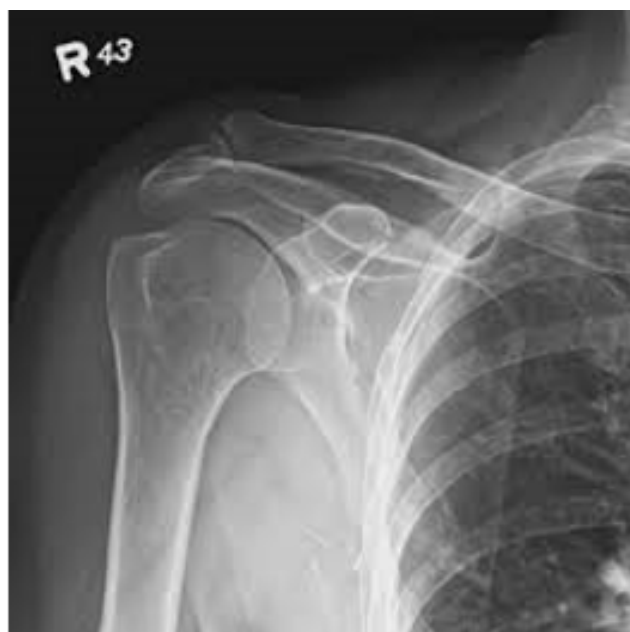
X-ray shoulder joint – fused
